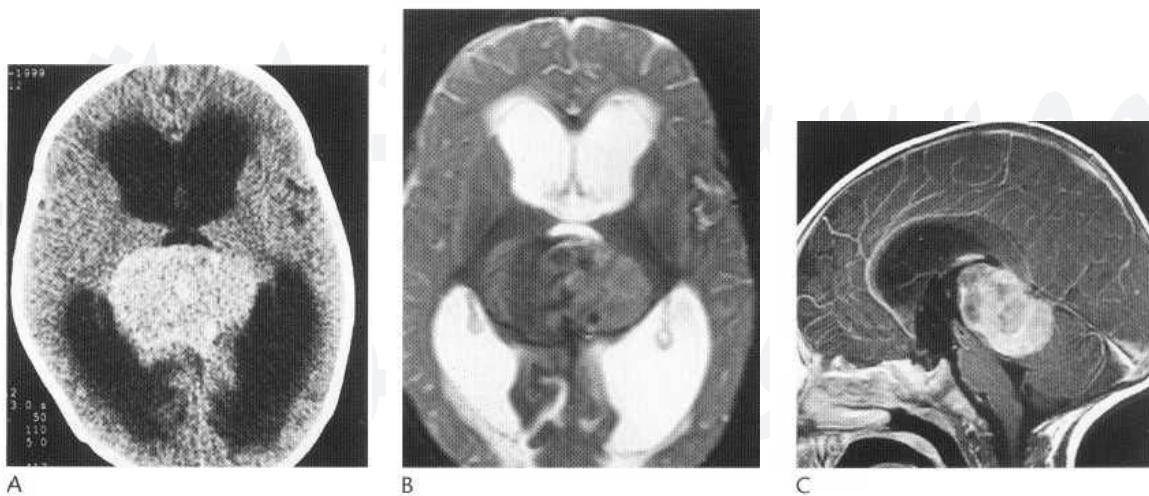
Pineal tumours. Axial postcontrast CT (A) showing an enhancing mass centred on the pineal region invaginating into the third ventricle and resulting in obstructive hydrocephalus with transependymal oedema. This was a proven pineoblastoma. On the axial T₂-weighted MR image (B) the mass is of slightly heterogeneous T₂ signal; enhancement is also slightly heterogeneous on the sagittal T₁ postcontrast image (C).
